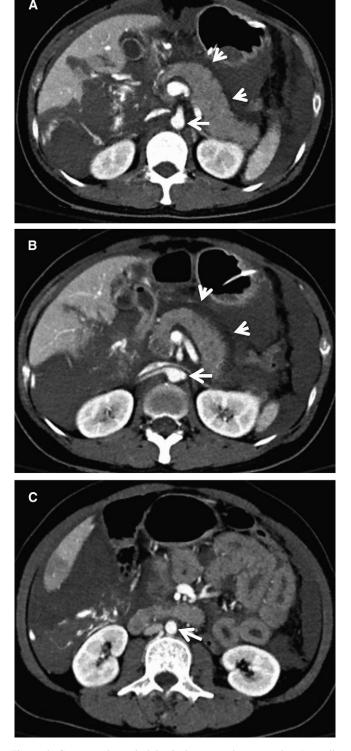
Contrast-enhanced abdominal computed tomography. A smallcalibre aorta (arrows) is demonstrated 2 cm above (A), at (B), and 2 cm below (C) the renal arteries. There is diffuse small bowel wall thickening and enhancement, dense renal cortical enhancement, a flattened inferior vena cava and peripancreatic oedema (arrowheads).
